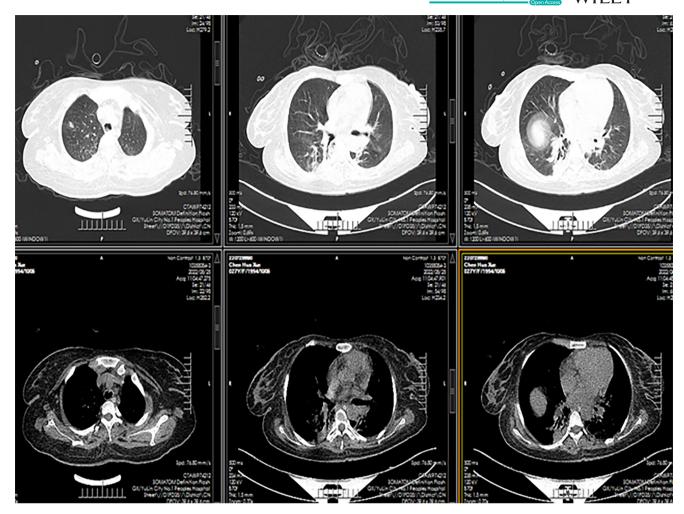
Pulmonary CT on the day of ECMO removal. On July 31, the two pneumonia lesions had decreased in size, and the pleural effusion on both sides had largely resolved.
